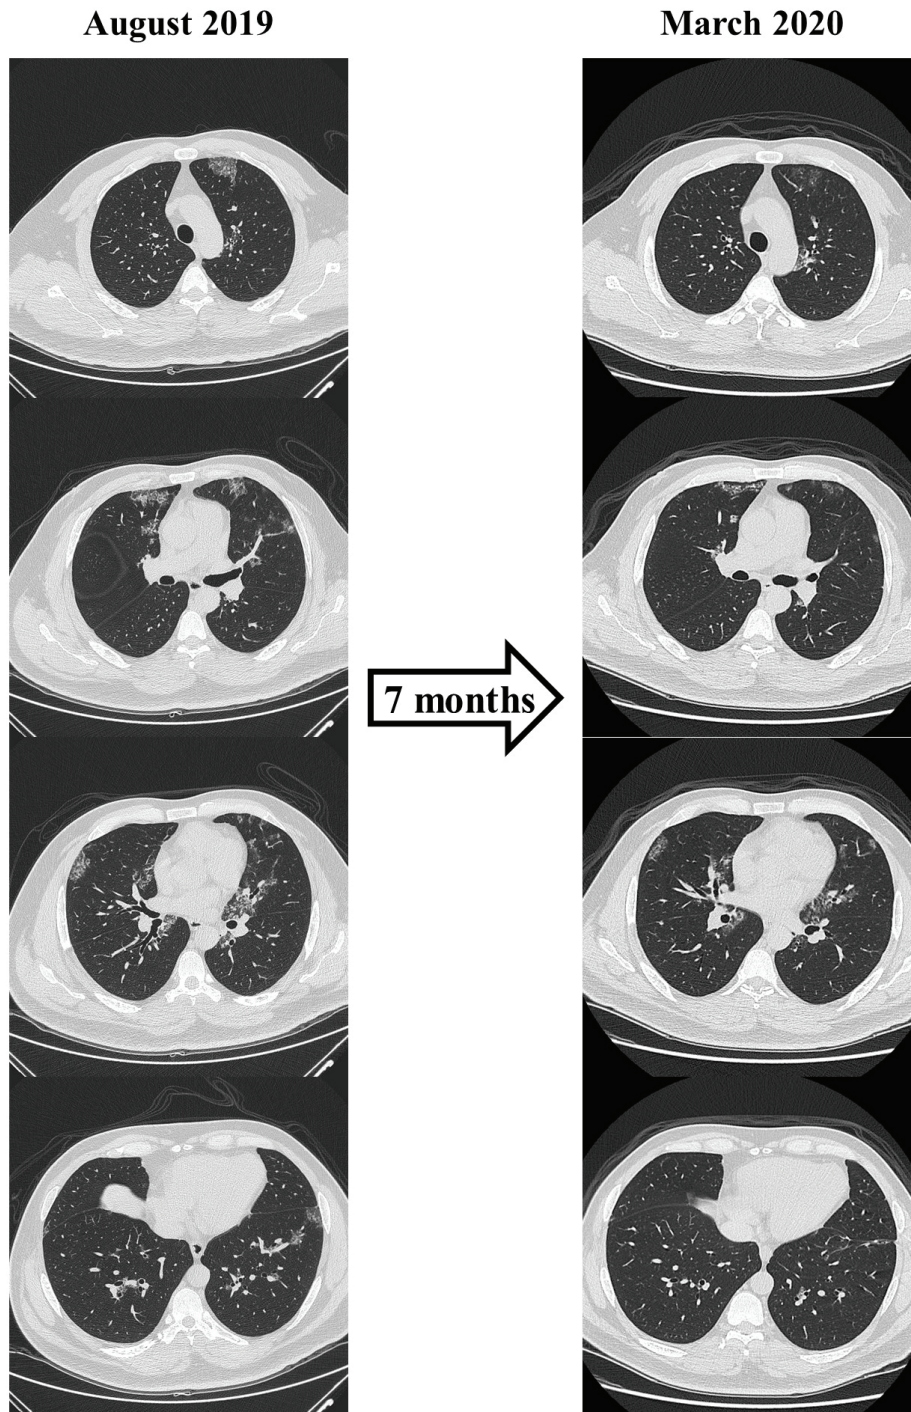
High-resolution computed tomography revealed a bilateral subpleural peri-bronchial crazy-paving pattern, with spontaneous improvement without treatment after 7 months.
